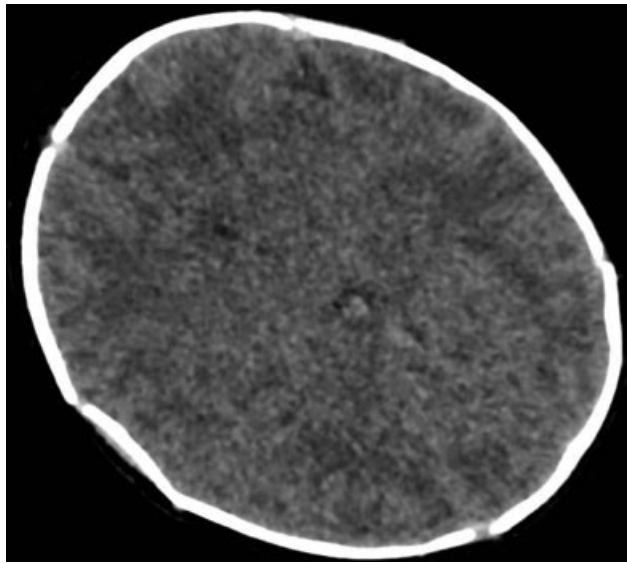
Computed tomography scan of the head – preprocedure.
